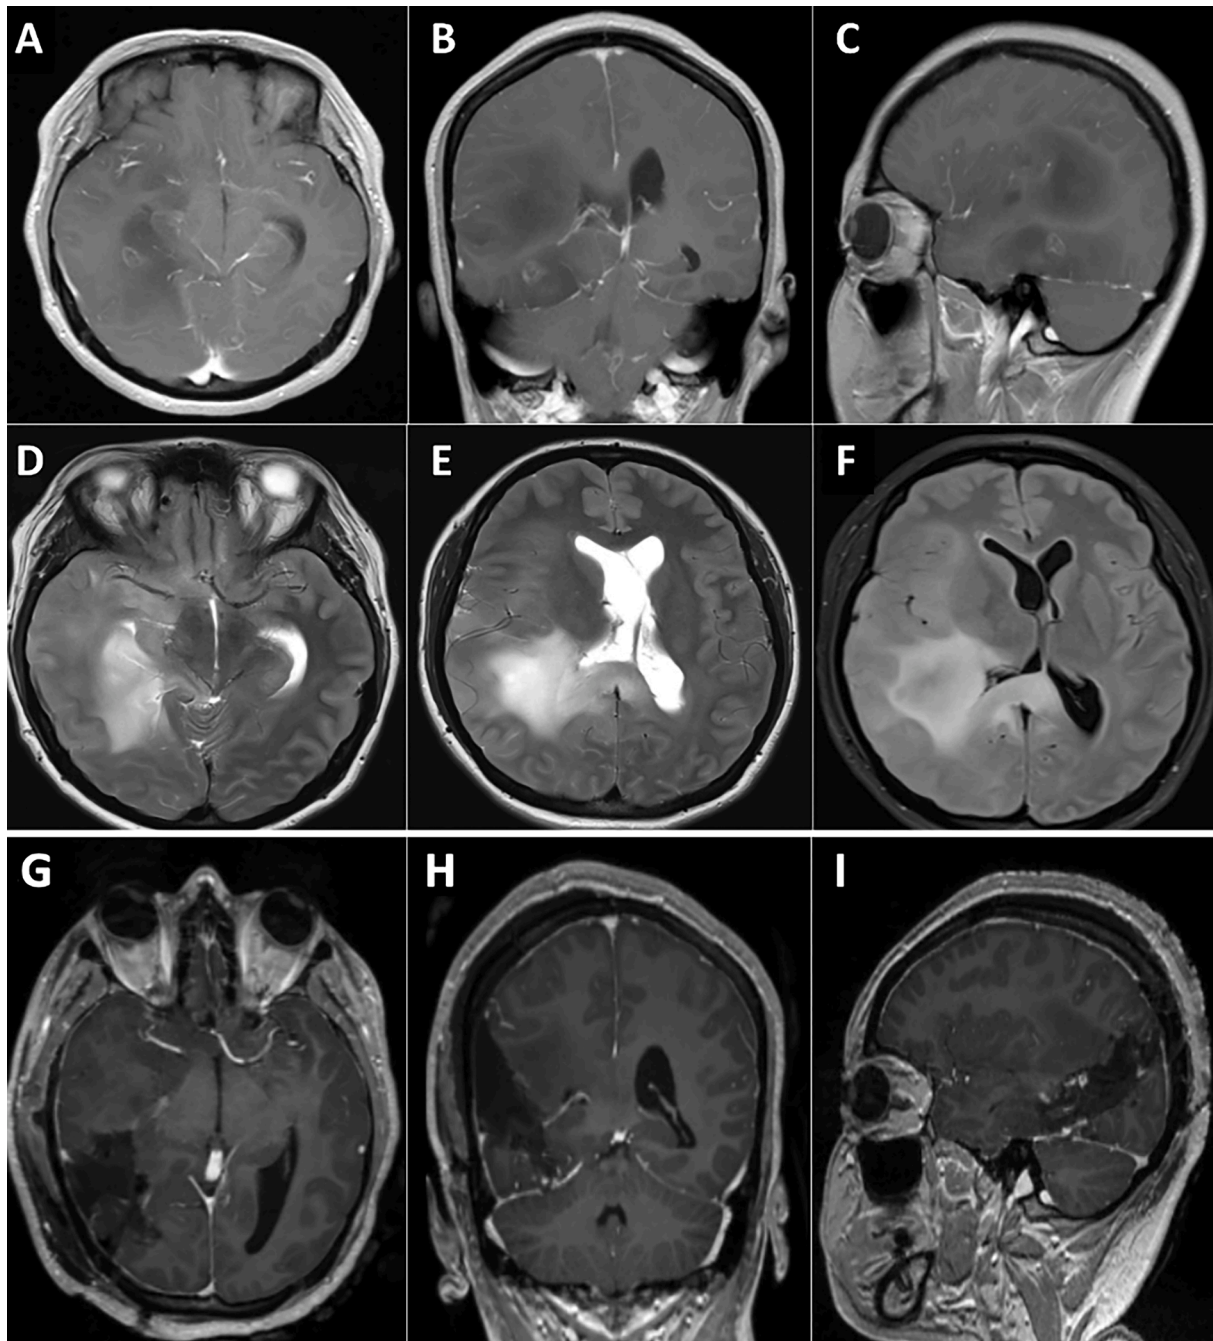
Pre-surgical brain 1.5 Tesla's MRI. T1WI with gadolinium in axial (A), coronal (B) and sagittal (C) sections, showing a hypointense subcortical lesion the tempo-occipital-parietal junction of the right hemisphere with an area of enhancement at the level of the inferior temporal gyrus, and displacement of adjacent structures. On T2WI (D and E) and FLAIR sequences (F), the lesion is hyperintense and a subcortical extension through the corpus callosum is evident. Post-surgical 1.5 Tesla's brain MRI. T1WI with gadolinium in axial (G), coronal (H) and sagittal (I) sections shows postsurgical changes, without evidence of contrast-enhancing lesions.
